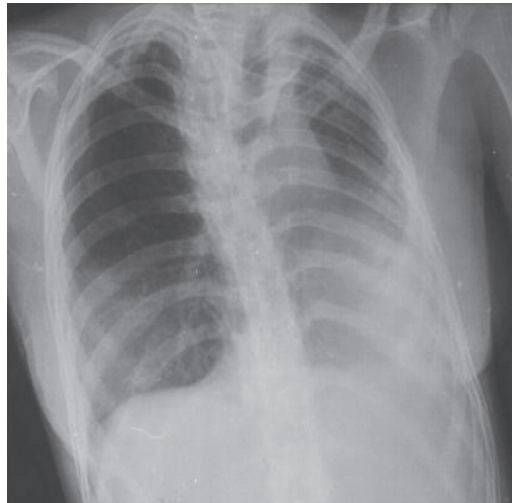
Chest x-ray after drains remotion
